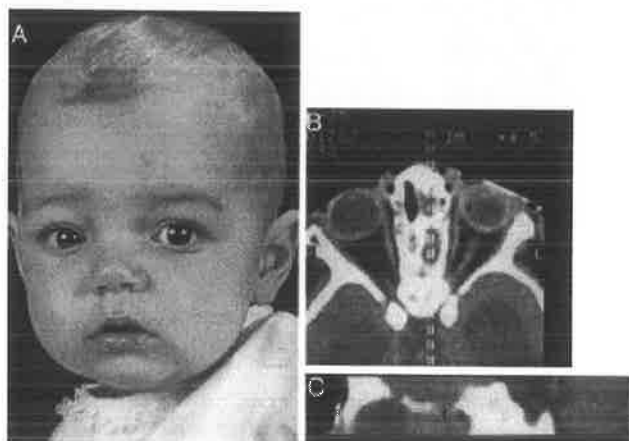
A—C, patient with a basal meningoencephalocele of the transethmoid variety. A CT sagittal reconstruction through the cribriform region shows the exit hole (arrow).
